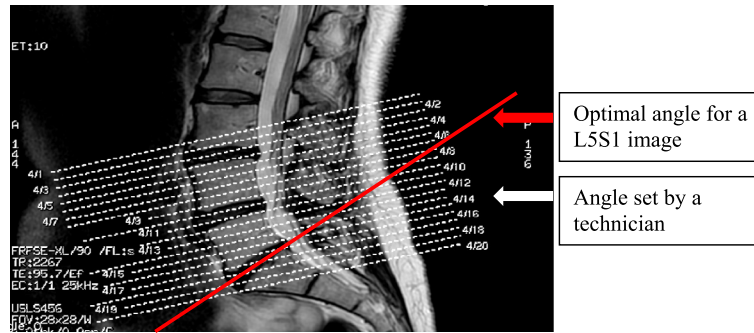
As in this example, routinely acquired MRI often do not provide cuts at the proper angle to assess canal cross-sectional area. The angle set during routine clinical imaging for all axial images is contrasted with the optimal angle for analysis of DCSA at L5–S1.
